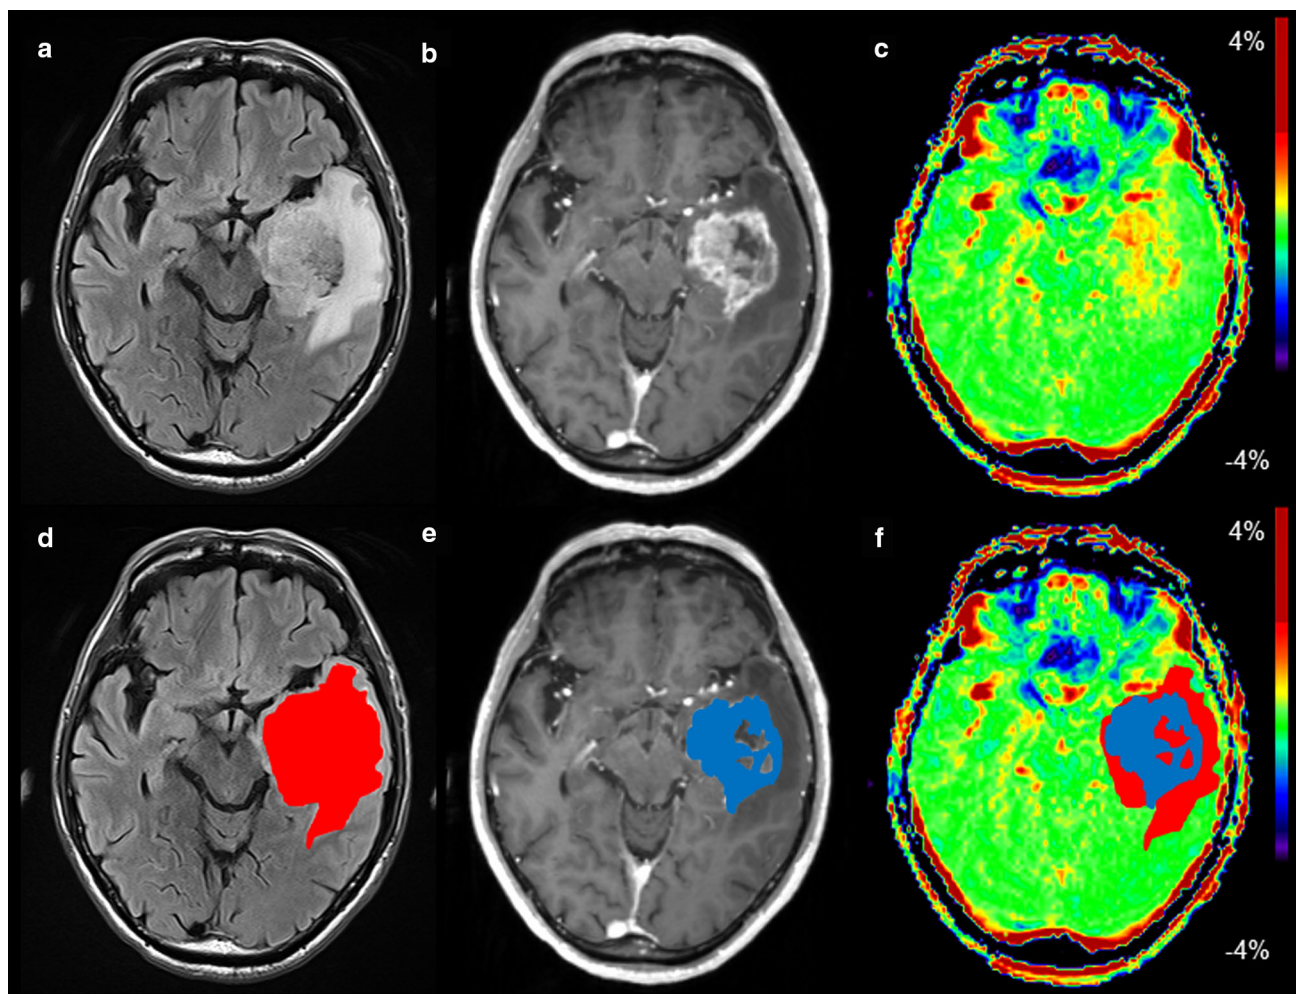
A representative case of a 72-year-old man with glioblastoma (Grade 4) on FLAIR (a), contrast-enhanced T1-weighted images (b) and co-registered APTasym image (c). ROIs were drawn based on
